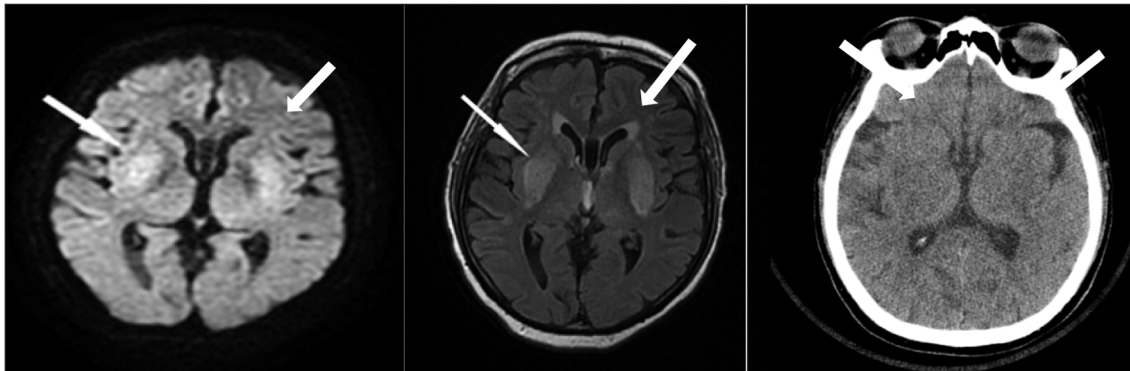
On the first day basal ganglia were seen hypodense on CT image; hyperintense on T2 weighted flair and diffusion sequences in MRI. Also the patient has cavum septi pellucidi and cavum Vergae variation.
